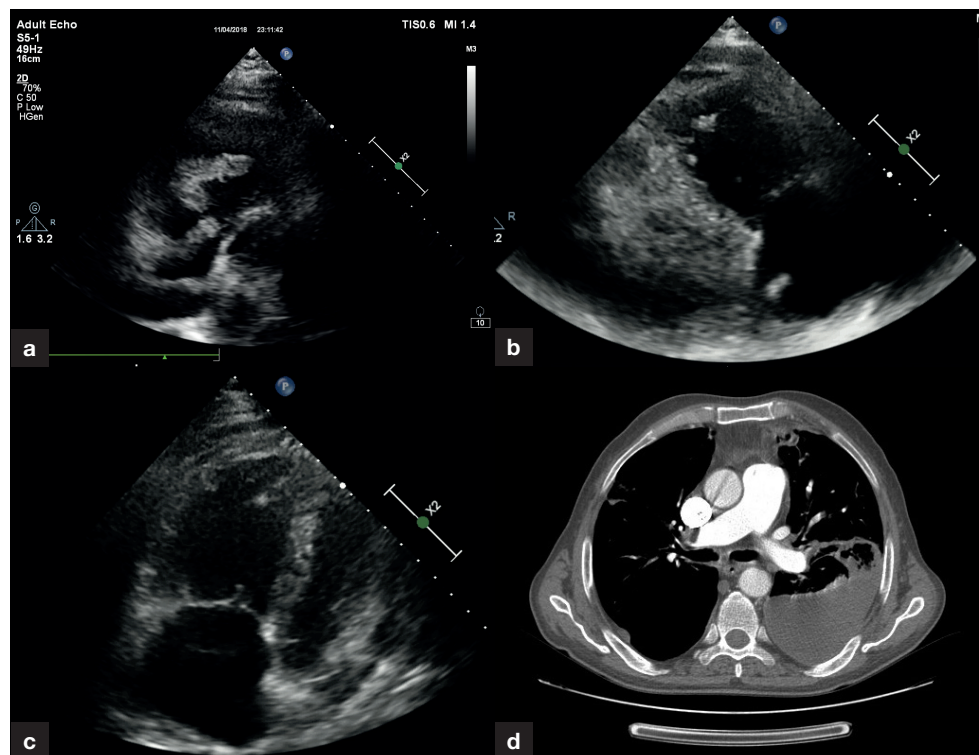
Transthoracic echocardiogram on admission showing (a) thrombus-in-transit in the right atrium and ventricle; (b) residual thrombus in the right atrium following the initial 25 mg tissue plasminogen activator over 25 hours; (c) complete resolution of thrombus in the right heart following administration of 50 mg tissue plasminogen activator over 50 hours; (d) computed tomography pulmonary angiogram confirming pulmonary embolism.
